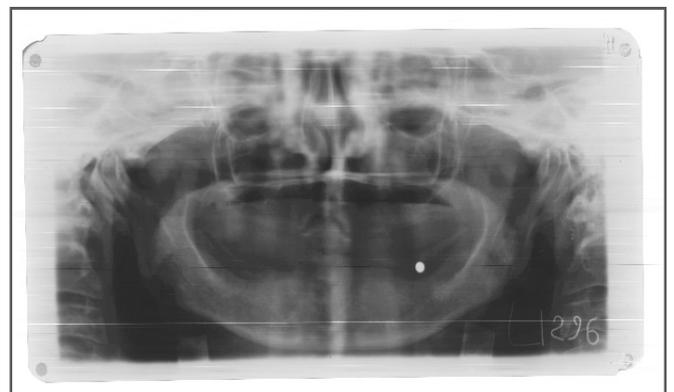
Scanned OPG showing 5mm radiographic marker
